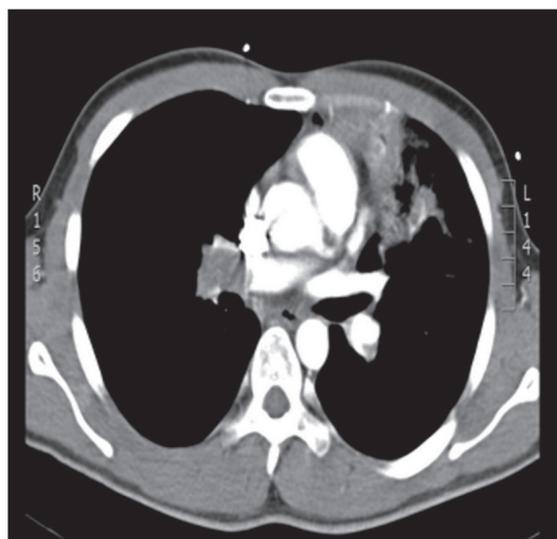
CT pulmonary angiogram of the patient in the case report revealing a large thrombus in the right main pulmonary artery.
